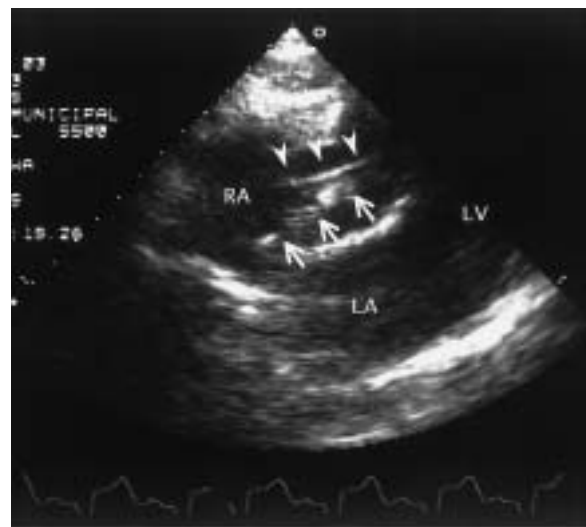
Postoperative echocardiogram in the sub-xiphoid view
